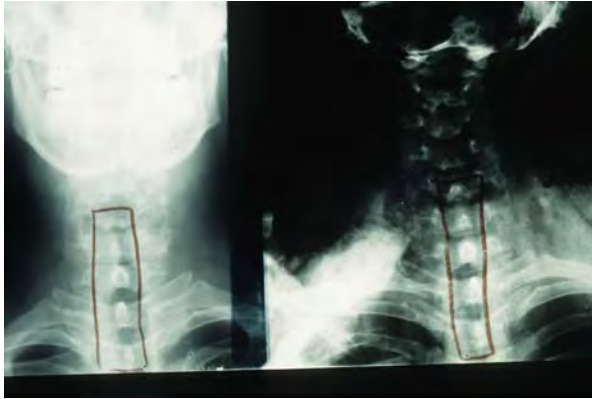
Left:* A close-up view of an antemortem (before death) neck X-ray, received from a hospital for comparison purposes. *Right:* A close-up view of a postmortem neck X-ray corresponding to the antemortem film. Note that the unique shapes of the spinous processes of the vertebral column in each X-ray are identical, allowing for positive identification
